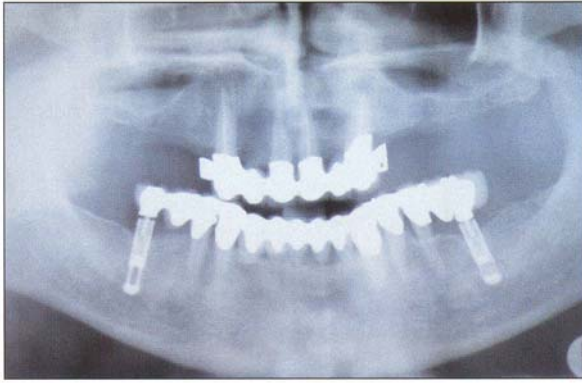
Panoramic radiograph of a 54-year-old patient.
